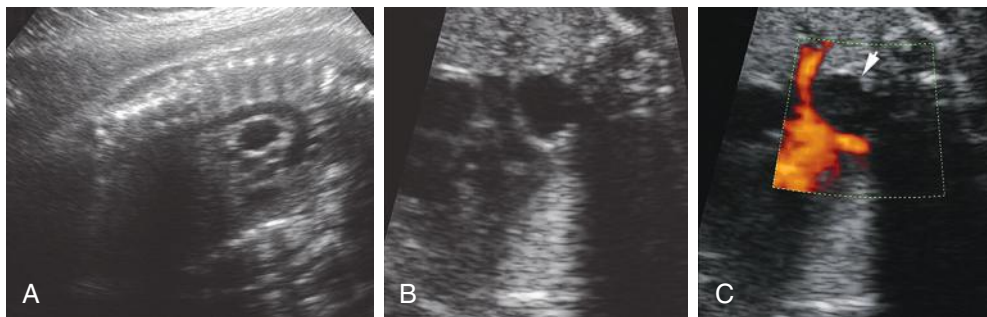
Bronchogenic cyst (*arrow*) in fetus at 28 weeks' gestation, shown in longitudinal (A) and transverse (B) planes and transverse image with power Doppler sonographic evaluation (C).
